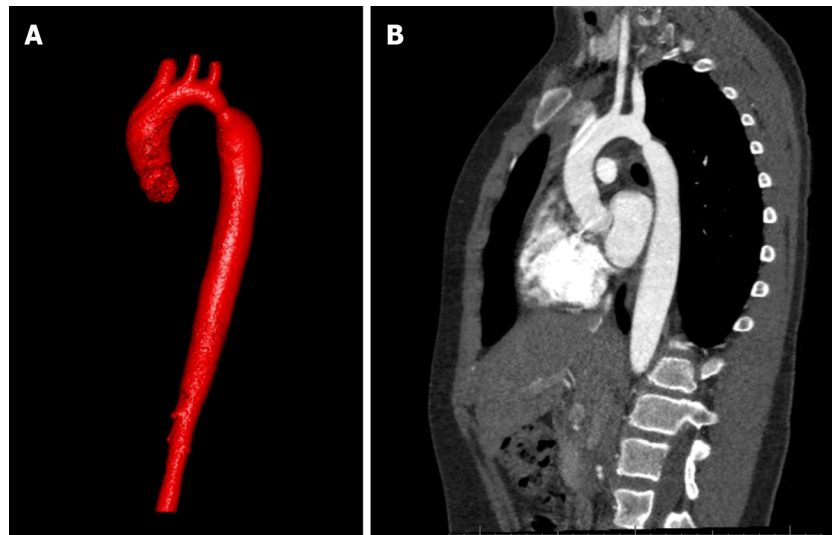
Contrast-enhanced computed tomography demonstrating coarctation of aorta. A: 3D reconstruction image; B: Sagittal cross-sectional view.
